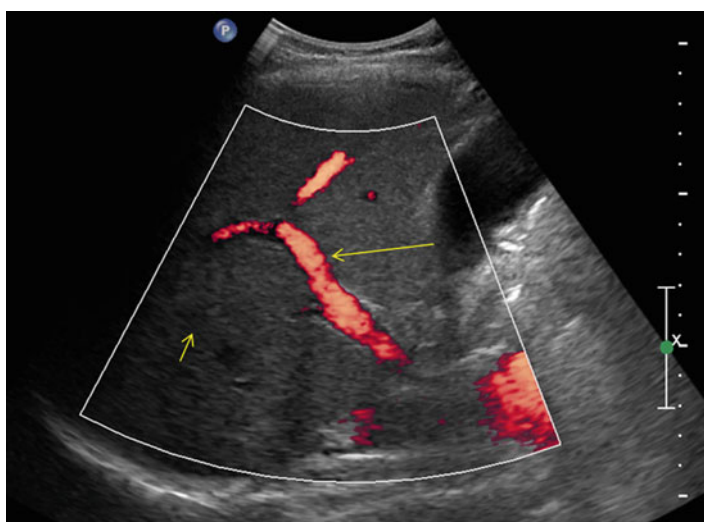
Power Doppler. The power Doppler image displays patent flow within the portal vein (*long arrow*) of the liver (*short arrow*). No quantitative information is provided in regard to the direction of flow or the magnitude of the velocity
